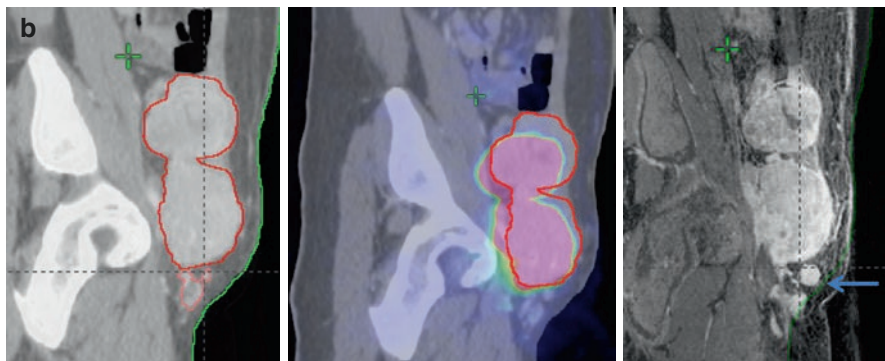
Pretreatment CT of the abdomen/pelvis (*left panel*) shows a multi-lobulated mass of the abdominal wall in a teenage male. Biopsy showed high grade leiomyosarcoma. Axial PET-CT (*right panel*) showed FDG avidity in one inguinal lymph node adjacent to the lower mass (blue arrow). The patient received a course of neoadjuvant chemoradiotherapy including 45 Gy with concurrent ifosfamide
